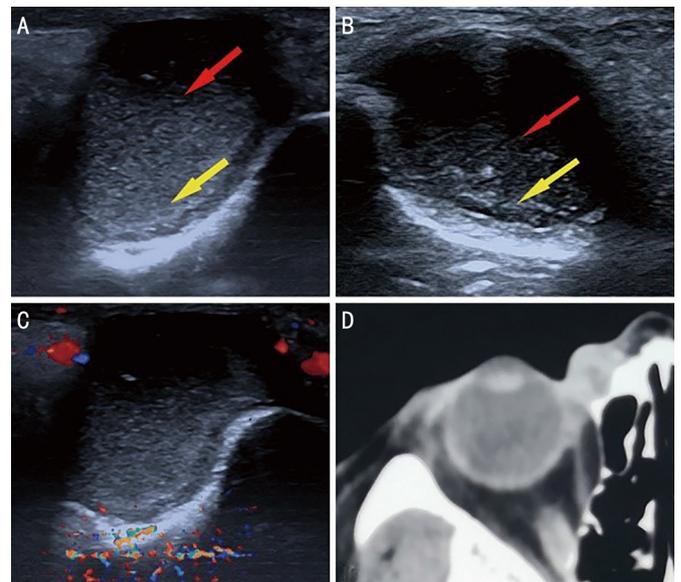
Imaging features of mucoceles in CDU and CT-DCG A and B: An oval shape and a “hill”-like shape with moderate-intensity flocculation echoes, which gradually increased from top to bottom. The echoes of the posterior wall of the lacrimal sac were significantly enhanced as detected in conventional ultrasound. The red arrow showed top echoes, and the yellow arrow showed bottom echoes. C: CDU showed no blood flow signal inside of mass; D: CT showed soft tissue mass in the lacrimal sac without obvious bone destruction. CDU: Color Doppler ultrasound; CT-DCG: Computed tomography dacrycystography; CT: Computed tomography.
